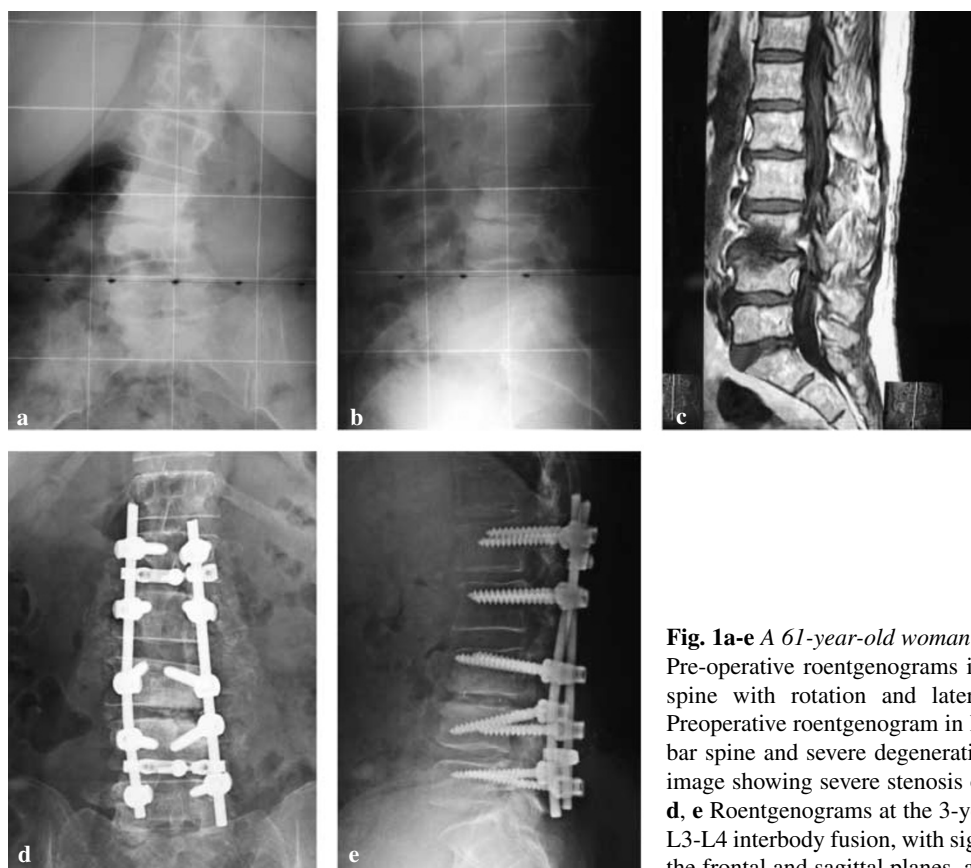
A 61-year-old woman with degenerative lumbar scoliosis. a Pre-operative roentgenograms in anteroposterior view of the lumbar spine with rotation and lateral listhesis at the L3-L4 level. b Preoperative roentgenogram in lateral view with kyphosis of the lumbar spine and severe degenerative changes at the L3-L4 level. c MR image showing severe stenosis of the spinal canal at the L3-L4 level. d, e Roentgenograms at the 3-year follow-up show posterolateral and L3-L4 interbody fusion, with significant reduction of the deformity on the frontal and sagittal planes, and restoration of the disk height
